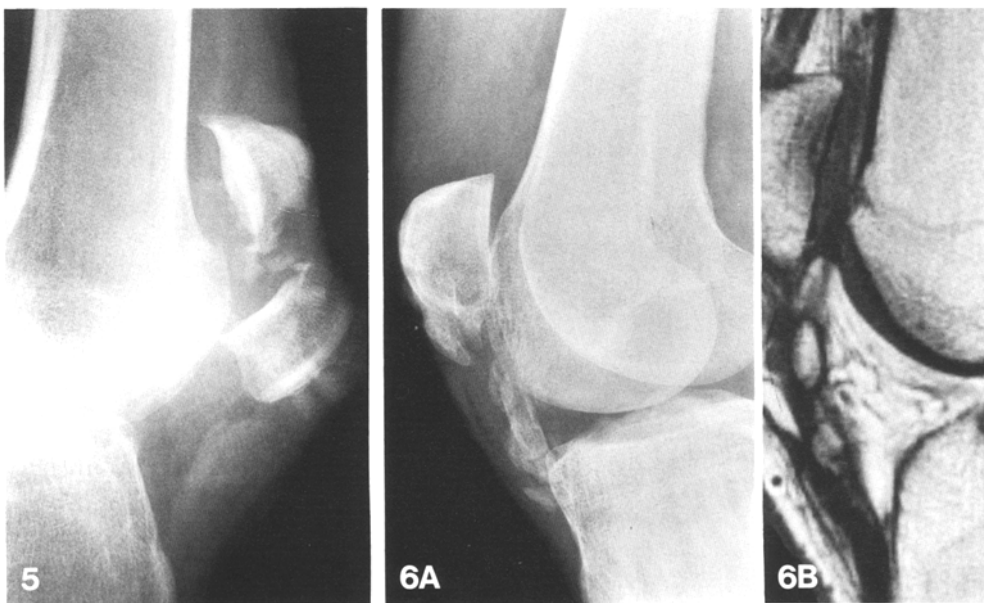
Lateral radiograph of the knee in a patient with a transverse patellar fracture. Patellar tendon has a “wrinkled” appearance
